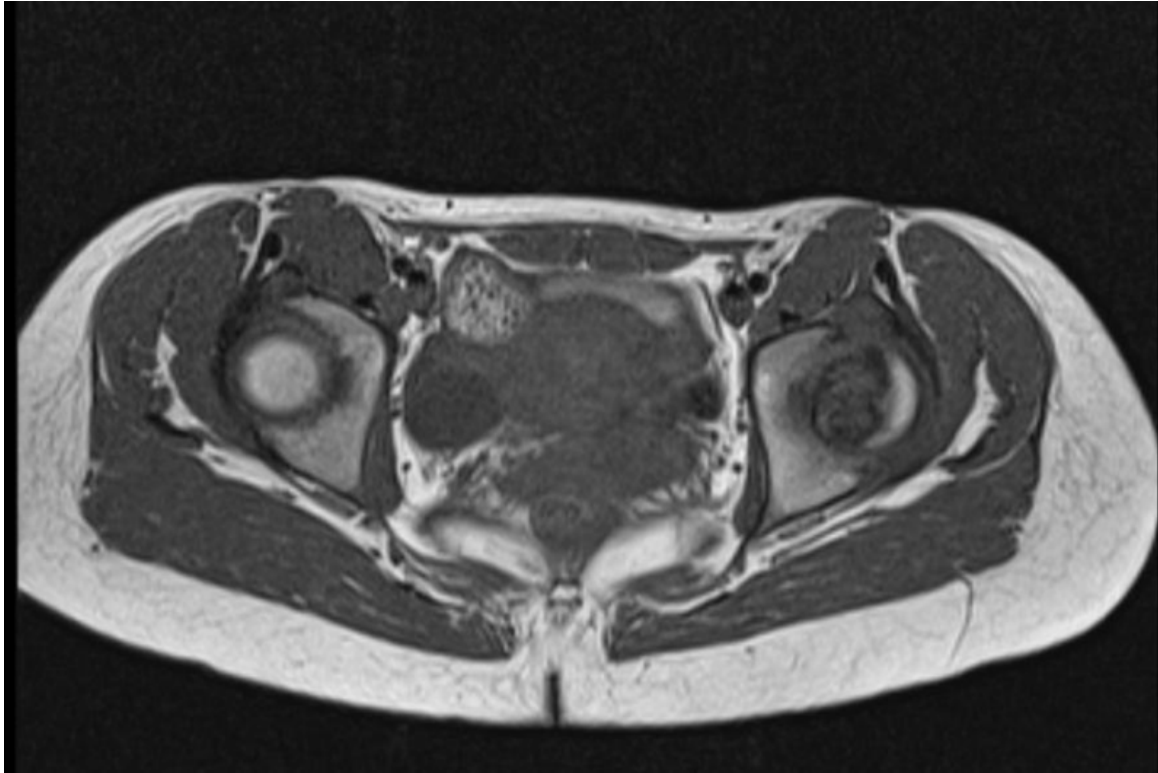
Preoperative MRI of the pelvis - transverse view
